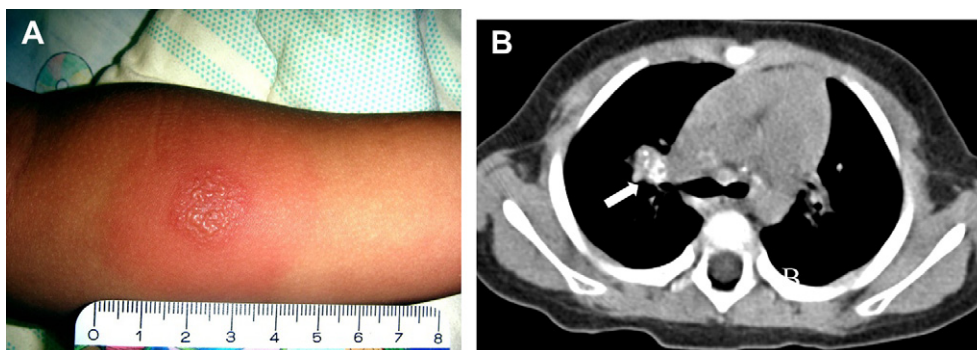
Primary tuberculosis (TB) infections with adenitis. A 22-month-old girl had not received Bacillus Calmette-Guérin (BCG) vaccination. Her grandmother was diagnosed with pulmonary TB. She had no fever, cough, or changes in bodyweight. (A) Tuberculin skin test showed induration larger than 40 mm with bulla formation. (B) The chest computerized tomography (CT) showed bulky calcifying lymph nodes (arrow) at right paratrachea, pretrachea, subcarina, and bilateral hilum.
